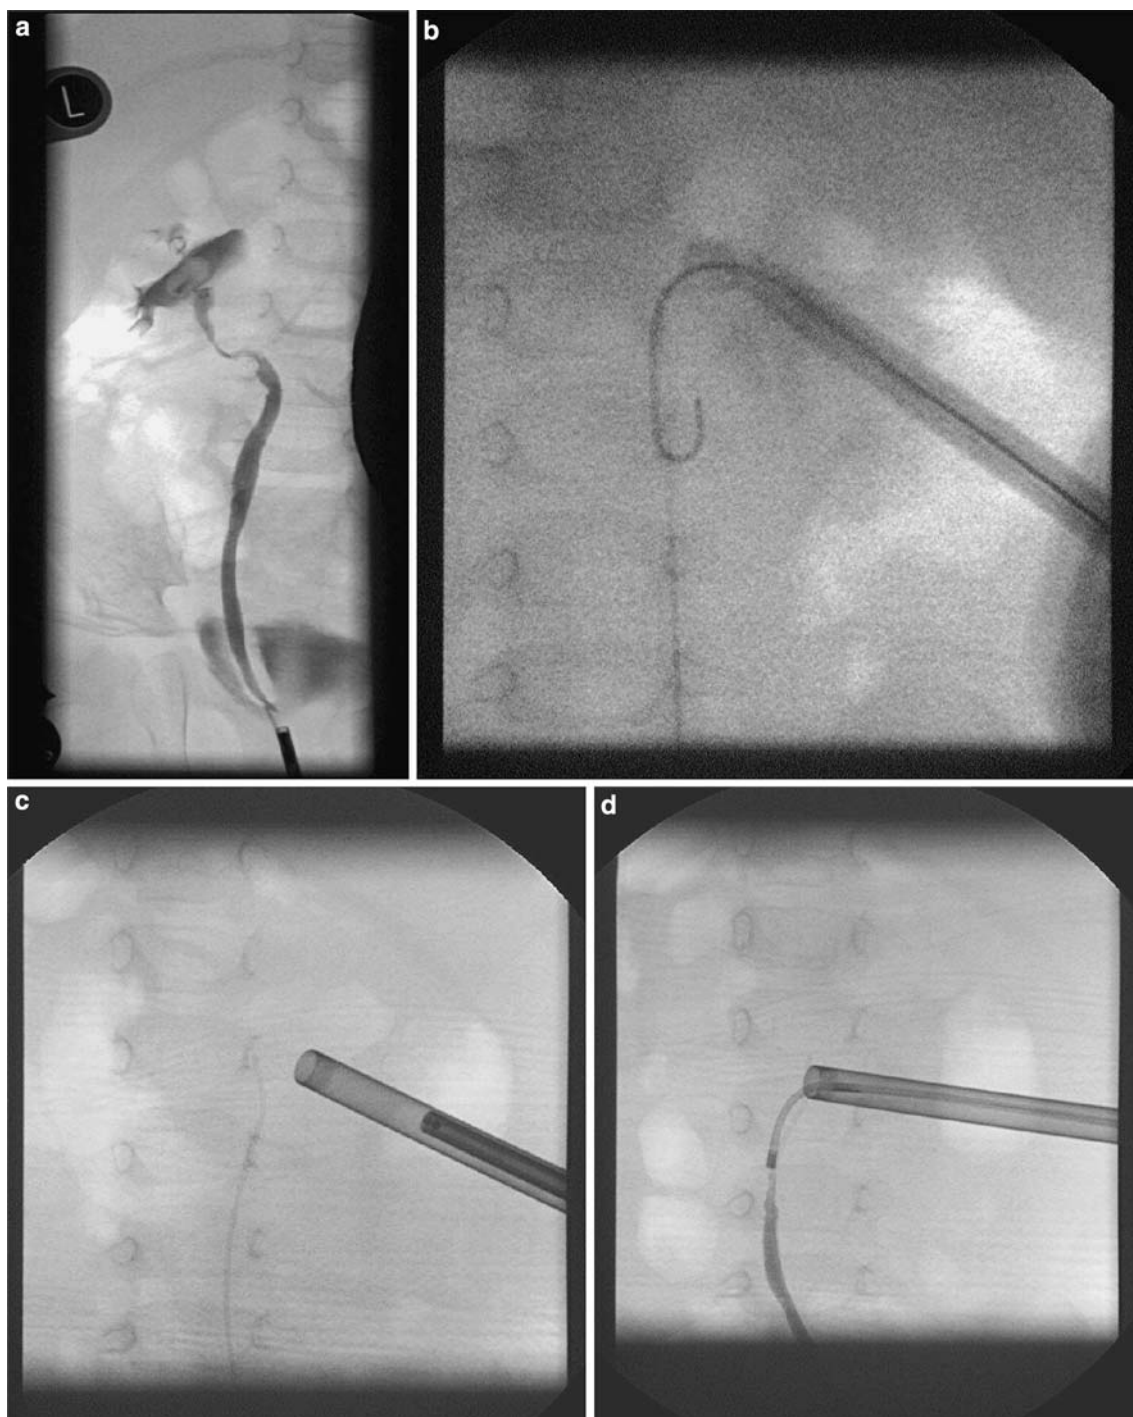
Minimal invasive PCNL in a 9-month-old female child. a Retrograde pyelography demonstrating a renal pelvic stone of the right kidney. b Insertion of an 18 F Amplatz sheath. c X-ray examination after removal of the renal stone. d Antegrade flexible
